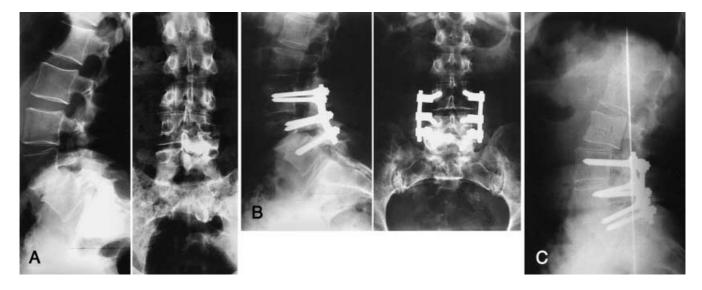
A This patient had lumbar lordosis of 18° and sacral inclination of 40° with antepulsion of plumb line pre operatively. B Immediate post operative radiographs showed improvement in lordosis to 34° and normalisation of plumb line. Sacral inclination had reduced to 30° . C Symptomatic retrolisthesis developed at the level above 6 years later
